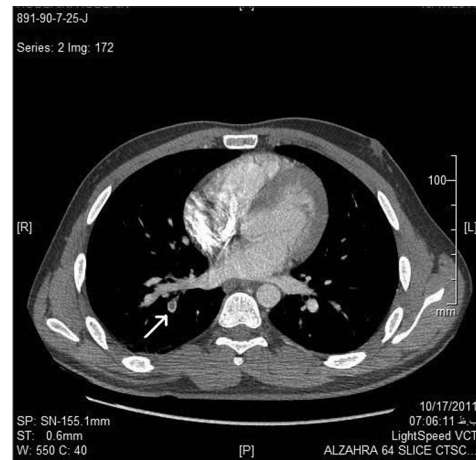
Thoracic CT shows filling defect in Segmental branch of RT lower lobe (arrow)
